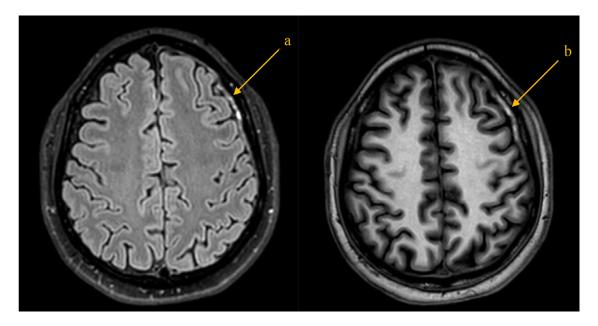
MRI brain with FLAIR (a) and T1 (b) sequences demonstrating shallow subacute subdural hemorrhage along the left cerebral convexity.
